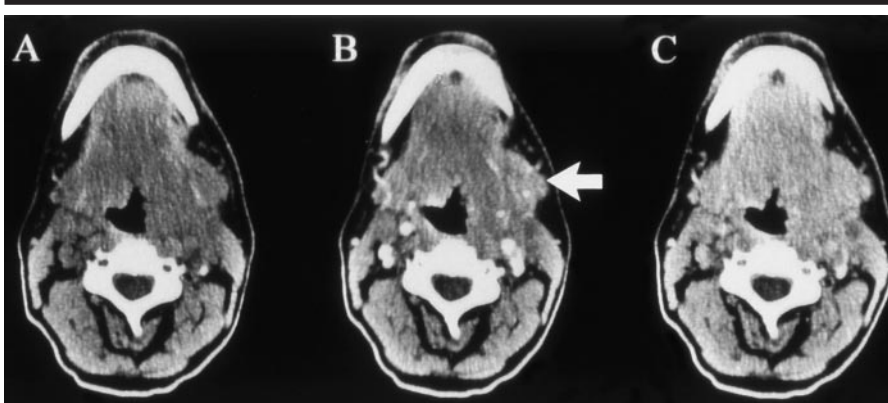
Patient 1. Three of 39 rapid transverse CT images from a dynamic CT data set obtained in a 40-year-old man with a squamous cell carcinoma (T4 N2c). The images were acquired with the same window scaling A, before; B, 30 seconds after; and C, 150 seconds after the onset of a 30-second-long, constant-rate administration of contrast agent. They demonstrate an advanced tumor (arrow in B) on the left, which asymmetrically compresses the hypopharyngeal region. The concentration-time courses determined from the carotid artery and from the tumor are shown in Figure 4a and 4b, respectively.
